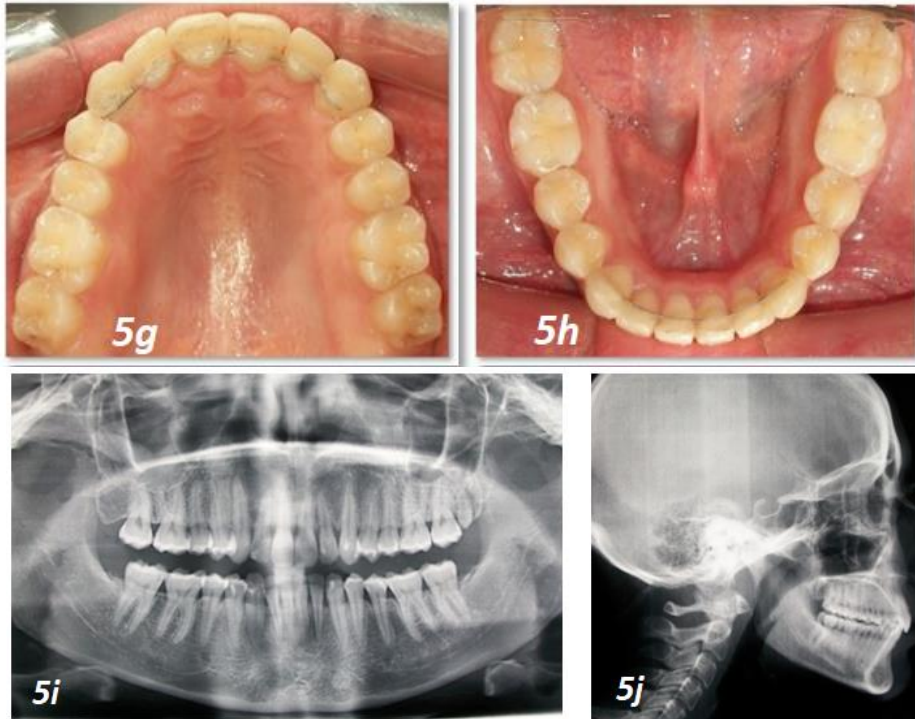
(a-j): Posttreatment photos and radiographs
